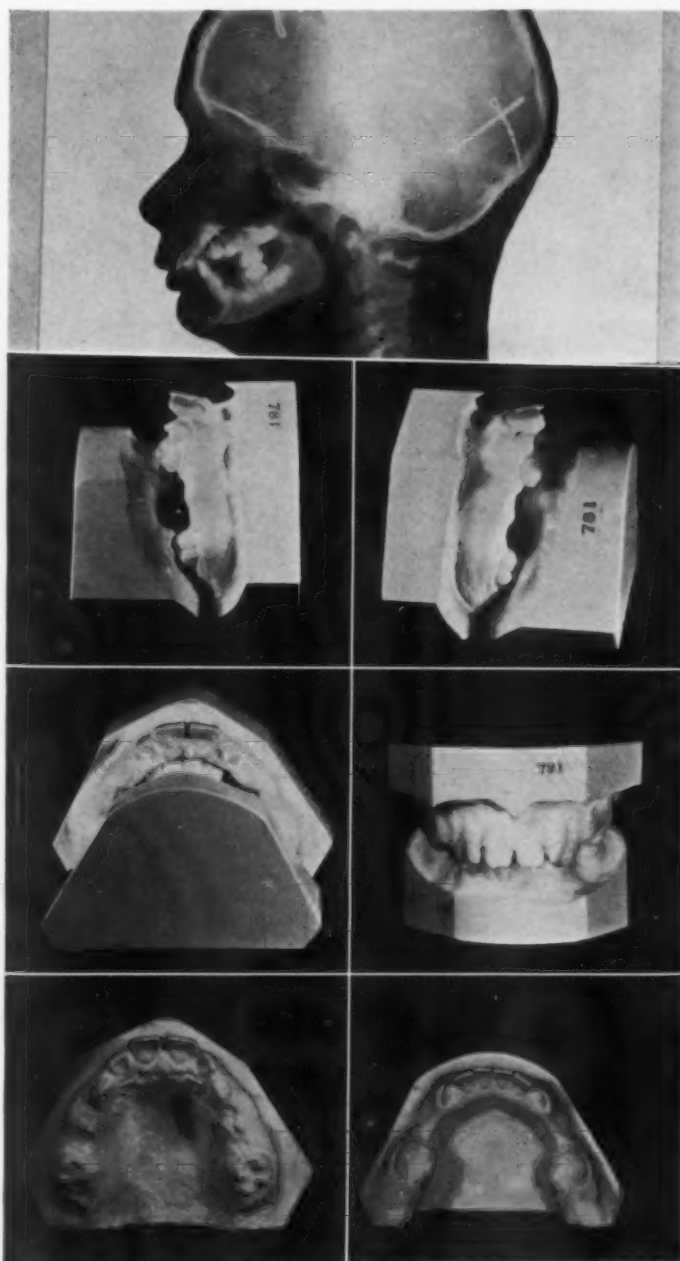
Headplate x-ray and models of a Type B, subdivision II case.
